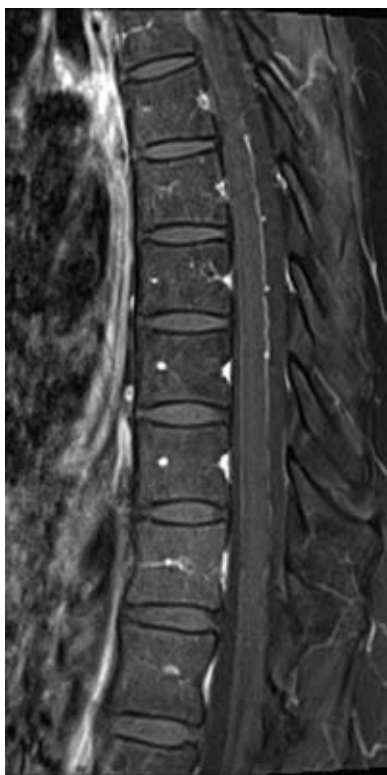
Normal MRI. Occasionally in a young patient who remains exceptionally still during an MRI examination, the conspicuity of normal vessels can be remarkable, as in this case. The distinguishing features from those of a patient with venous hypertension of the cord include the clinical history, absence of cord expansion or enhancement, absence of T2 signal hyperintensity within the cord, and a general *gestalt* of absence of tension (tortuosity) within the veins. Sometimes it can be difficult, but more generally the problem is not false-positive interpretation of normal MRIs, but rather the blurring of pathologic MRIs by patient motion and restlessness.
